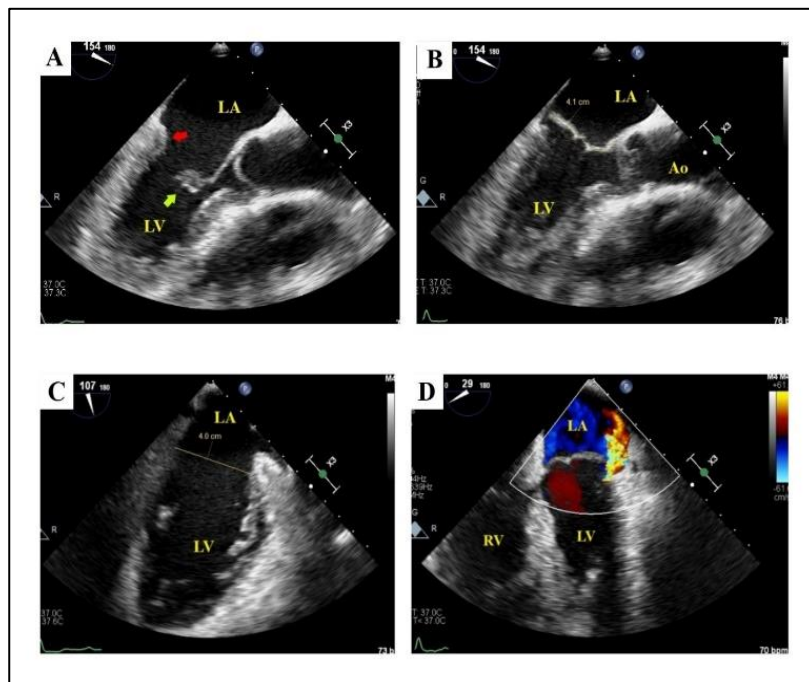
Transesophageal echocardiographic views in 150 and 100 degrees showing near absent posterior mitral leaflet (red arrow) with muscular continuation (A), anterior mitral leaflet is sail like, elongated (41 mm) and prolapsing (B), dilated bicommissural mitral annulus (40 mm) (C), moderate posteriorly directed jet of mitral regurgitation on long axis 29-degree view (D). Ao- Ascending aorta, LA- Left atrium, LV- Left ventricle, RV- Right ventricle
